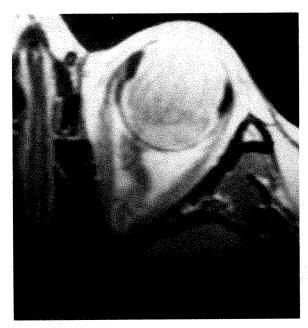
Figure (Smiddy, Michels, and Kumar). Left, Magnetic resonance image of eye with retinal detachment rotated superonasally. The retrobulbar segment of the optic nerve is taut and displaced laterally. This patient had undergone a previous scleral buckling operation, and the broad, hard silicone explant is visible (arrows). Right, The same eye in primary position. The retrobulbar segment of the optic nerve is loosely coiled and located more nasally.
